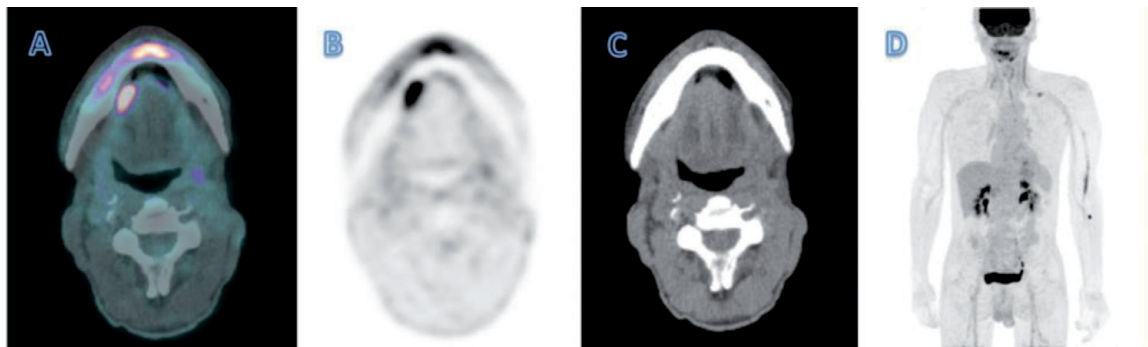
PET/CT with F18-FDG shows the high metabolism in the lesion in the floor of the mouth, without any local and remote metastasis in stem-body scan. (A) Fusion image, (B) PET, (C) CT, and (D) stem-body scan.
